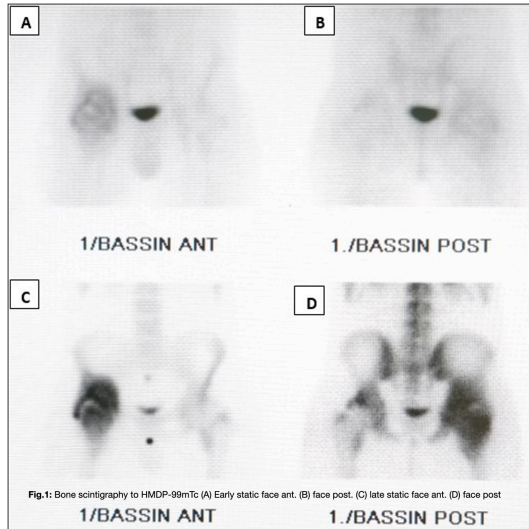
Bone scintigraphy to HMDP-99mTc (A) Early static face ant. (B) face post. (C) late static face ant. (D) face post
